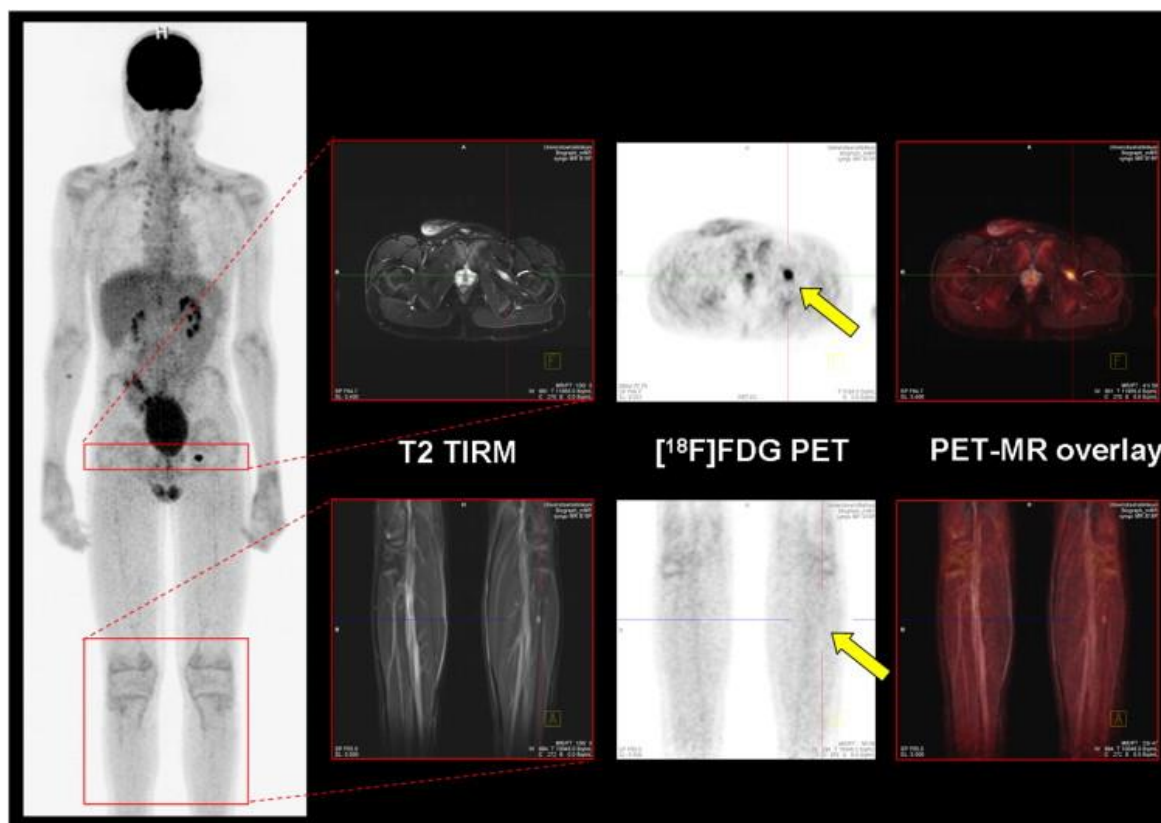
Simultaneous whole-body PET/MRI acquired with a molecular MR (mMR) scanner in a 13-year old boy with a Ewing sarcoma known for six years. The patient underwent standard chemotherapy together with autologous stem cell transplantation. After *i.v.* injection of [ $^{18}\text{F}$ ]FDG whole body PET-MRI was carried out. MR resulted in two suspicious lesions: One in the left upper leg muscle region, and one in the left lower leg. While the lesion in the left upper leg muscles showed intense [ $^{18}\text{F}$ ]FDG uptake, the other one was PET-negative (arrows). Follow-up confirmed a Ewing sarcoma relapse in the left upper leg muscle region. (Reprinted from (59), Copyright (2014), with permission from “Elsevier” and Prof. Dr. med. O. Sabri).
